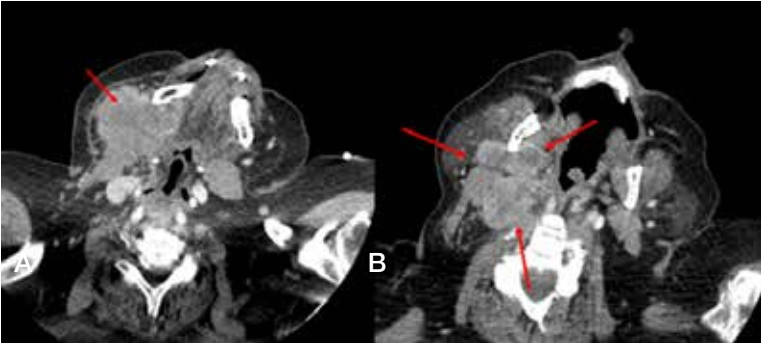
Computed tomography of neck with contrast demonstrated a large necrotic lymphadenopathy in the right submandibular (A), and a large necrotic lymphadenopathy in right level IIa stations (B).
